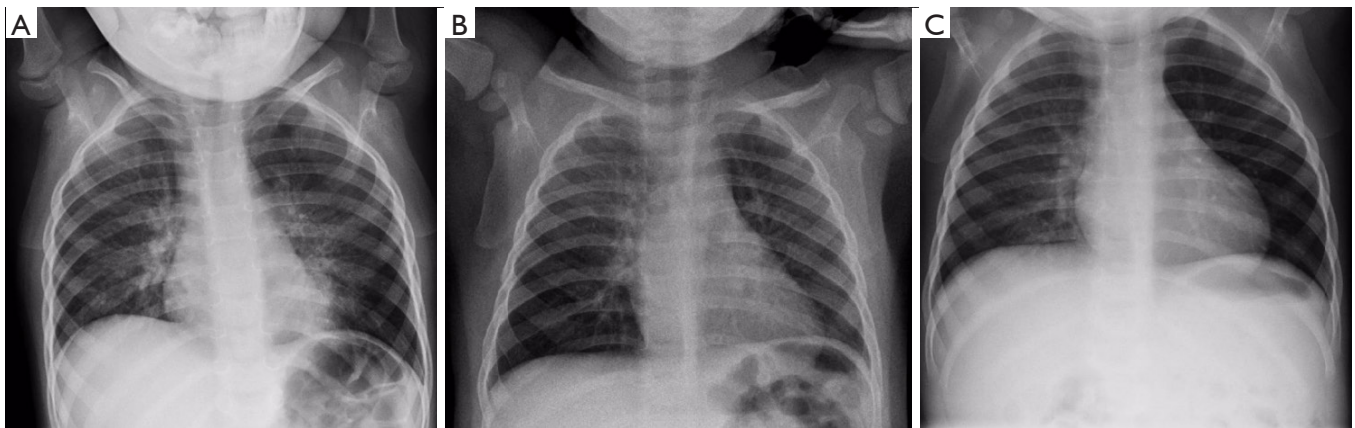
CXR showing: (A) left sided consolidation; (B) right upper lobe collapse; and (C) left sided hyperinflation. CXR, chest radiography.
